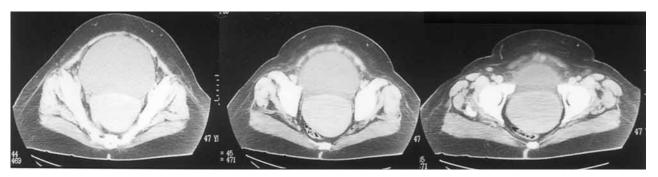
Computed tomography scan showing overextension of the urinary bladder and an enlarged fibroid uterus compressing the bladder neck and rectum.
